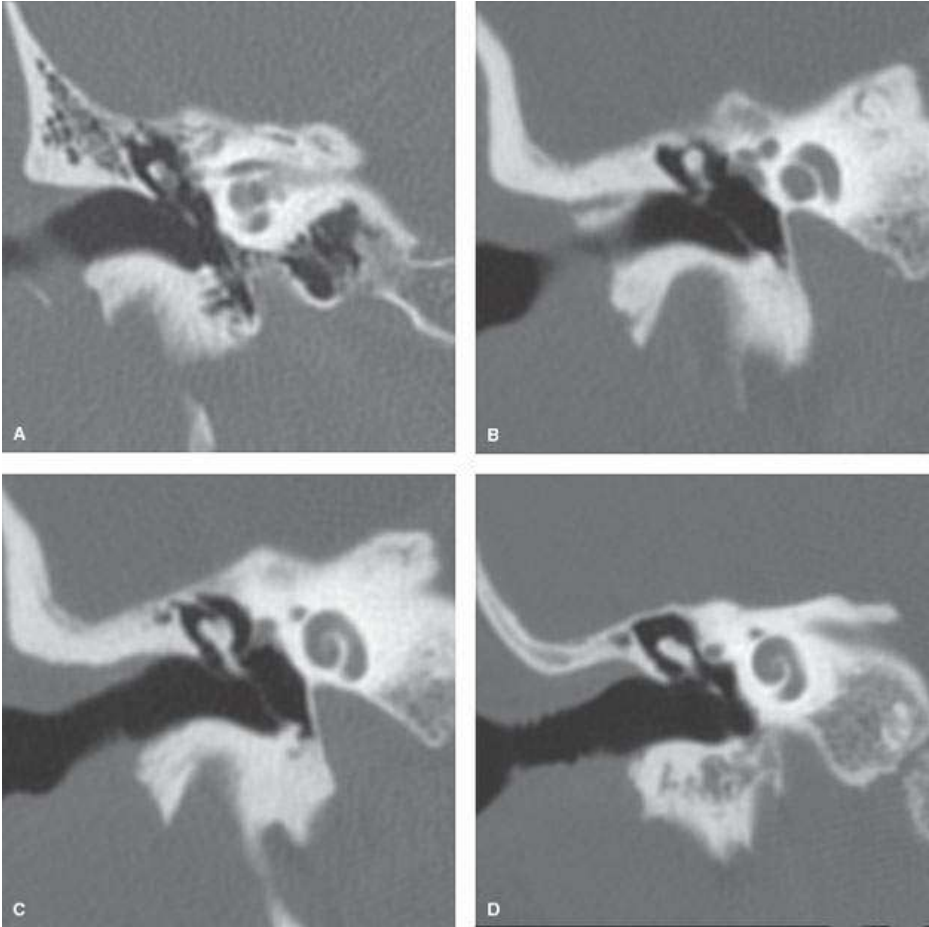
A–D: Anatomic variants of the scutum as seen on CT. The scutum differs in size and configuration but should always be pointed.
